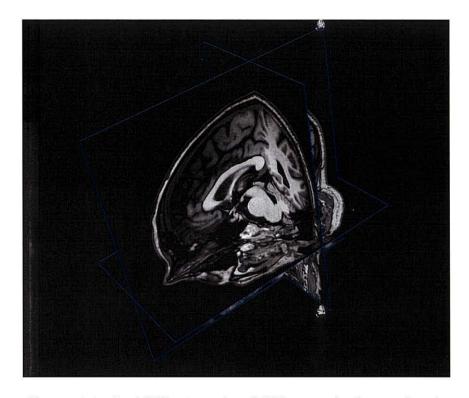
An MPR view of an MRI scan of a human head.
